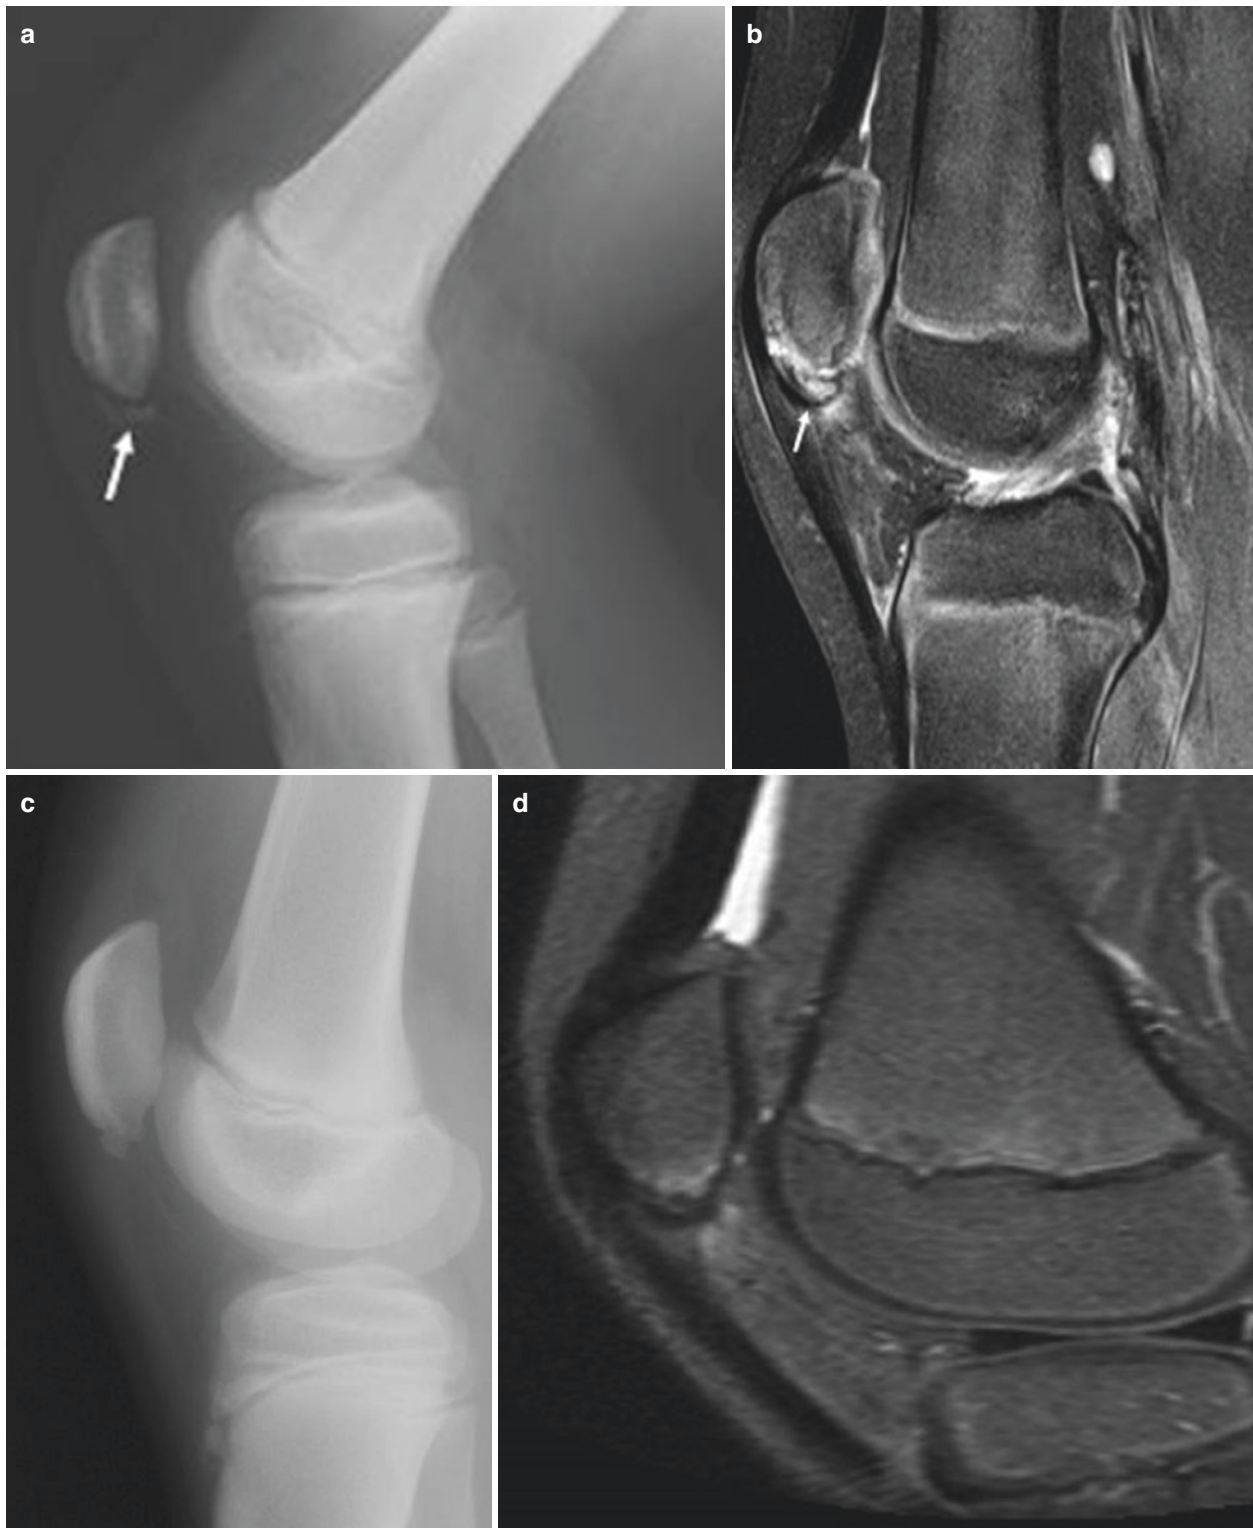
(a, b) Acute patellar sleeve fracture: Lateral radiograph (a) and sagittal T2-weighted image with fat suppression (b) in 11 y.o. boy with acute anterior knee pain after landing on his flexed knee when tackled from behind in football show a thin inferior patellar fracture fragment (arrow) and associated marrow and soft tissue. The patellar tendon is intact. (c, d) Proximal patellar tendon traction apophysitis, Sinding-Larsen-Johansson: Lateral radiograph (c) and sagittal T2-weighted image with fat suppression (d) in a 9 y.o. female ice skater with months of inferior patellar pain show fragmentation
